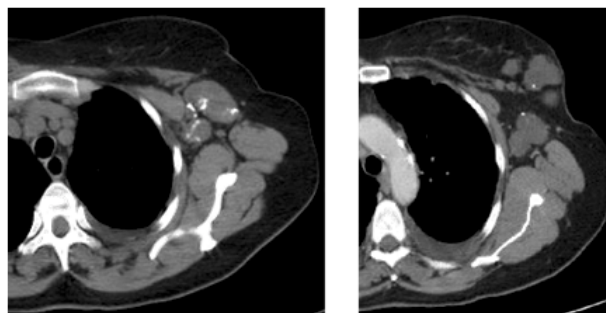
Computed tomography - Mucinous carcinoma of the left breast with massive coarse calcifications into the breast lesion and axillary lymph nodes
